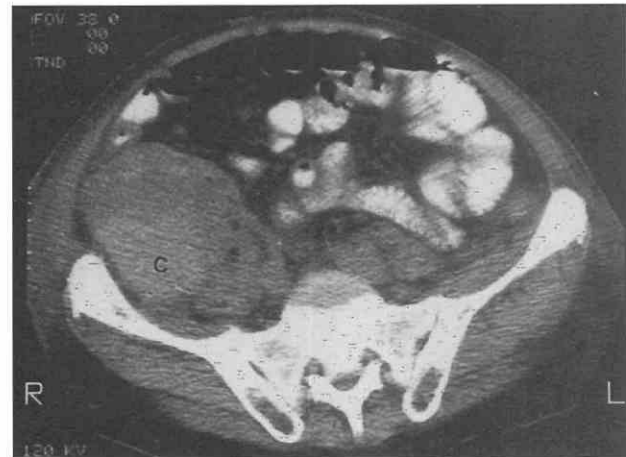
Spontaneous psoas hematoma in a patient receiving anticoagulant therapy. Unenhanced CT scan shows a retracting clot (C) with higher attenuation layering dependently.
